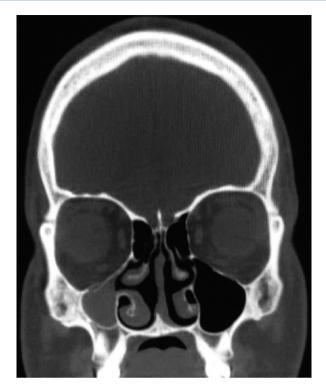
Non-contrast coronal CT scan of silent sinus syndrome
